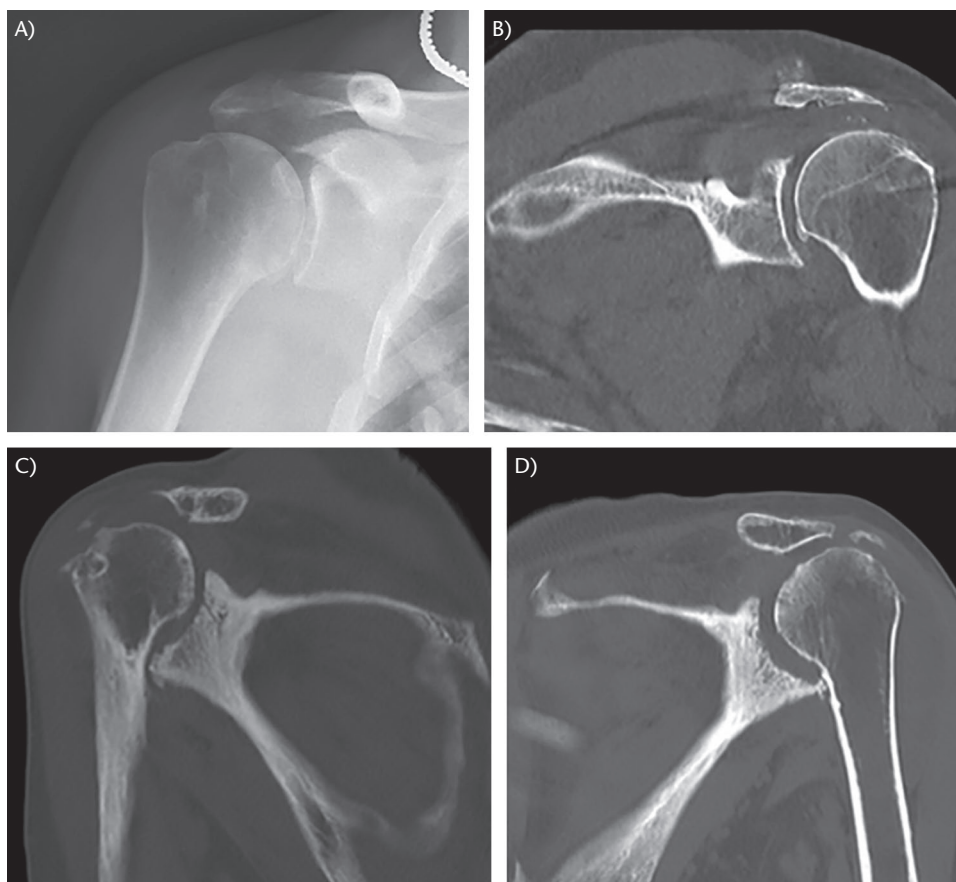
Favard type E glenoids. (A) E0: superior humeral head migration without glenoid erosion, on true AP radiograph. (B) E1: concentric glenoid erosion, on coronal CT. (C) E2: superior erosion limited to the superior glenoid, on coronal CT. (D) E3: erosion extending to the inferior glenoid edge, on coronal CT.
